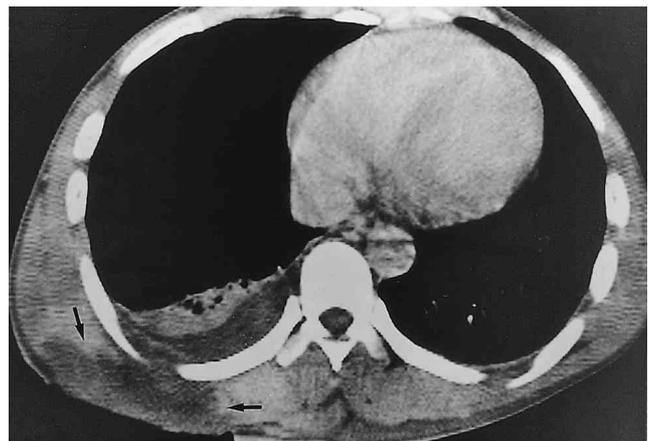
Soft tissue injury in a 45-year-old man with electric burn. Chest CT scan taken on the day of electrical burn shows a low-attenuated soft tissue lesion (arrows) due to tissue necrosis at the point of exit of electrical current. Note also defect of the overlying skin. Reactive pleural effusion and passive atelectasis seen in the right lung.
